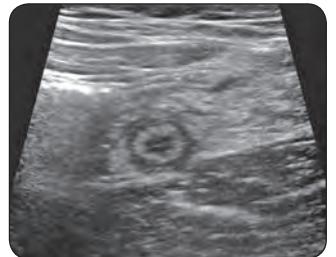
Ultrasound: inflamed appendix
